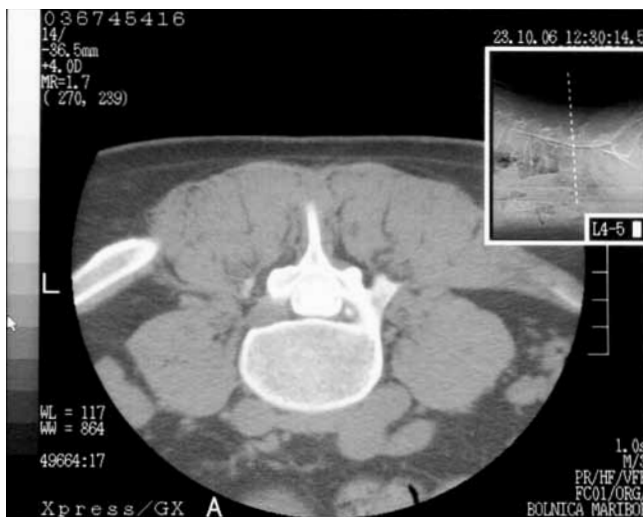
CT myelography revealed a minor left-sided lateral herniated disc at the level L4-L5.
